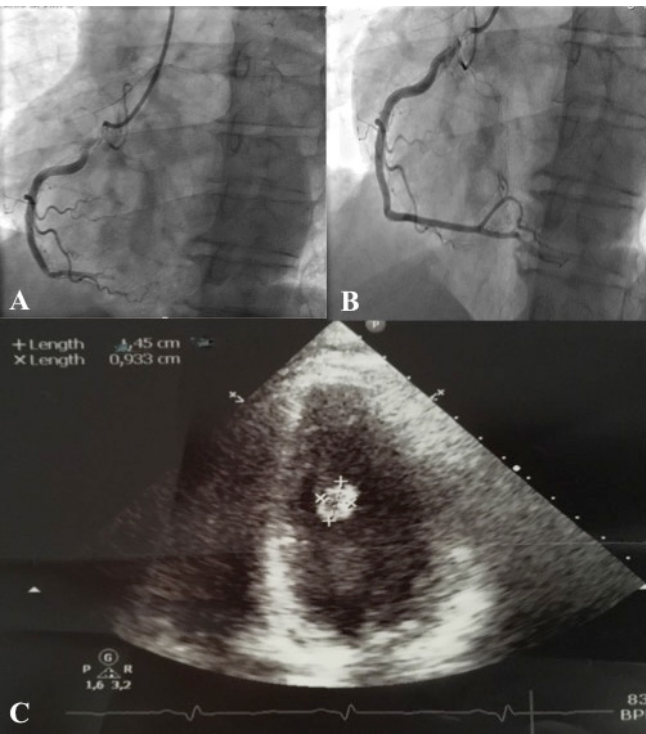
A) Coronariography showing right coronary occlusion. B) Final result after percutaneous treatment. C) Echocardiography showing a para-mitral valve mass of 1.5 cm.
